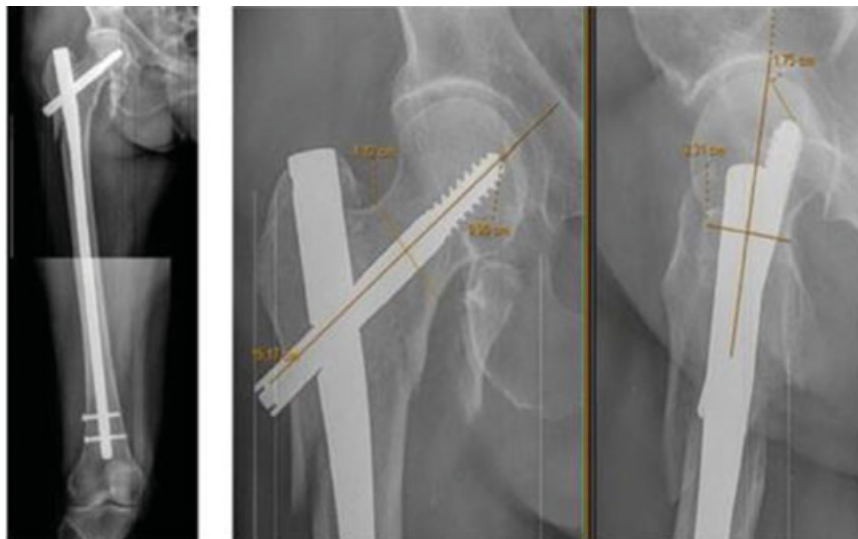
Right femur AP radiographs + AP and right hip profile showing TAD calculation.
